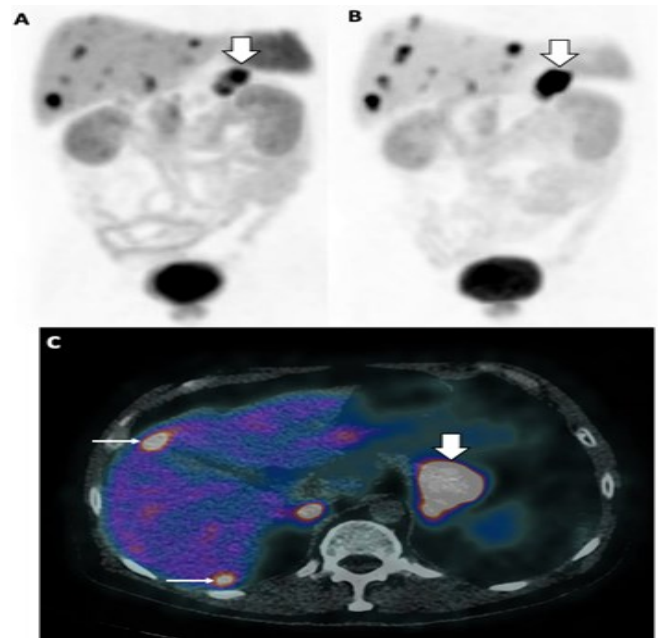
Maximum intensity projection (MIP) images of the Ga-68 DOTATATE PET-CT scans on baseline dated September 2018 (A) and after four months of somatostatin analogue therapy dated January 2019 (B) showing interval increase of SSTR expression in the pancreatic tail tumor (thick arrow). Fused PET-CT image (C) shows DOTATATE-avid lesions in the pancreatic tail (thick arrow) and liver (thin arrows).
